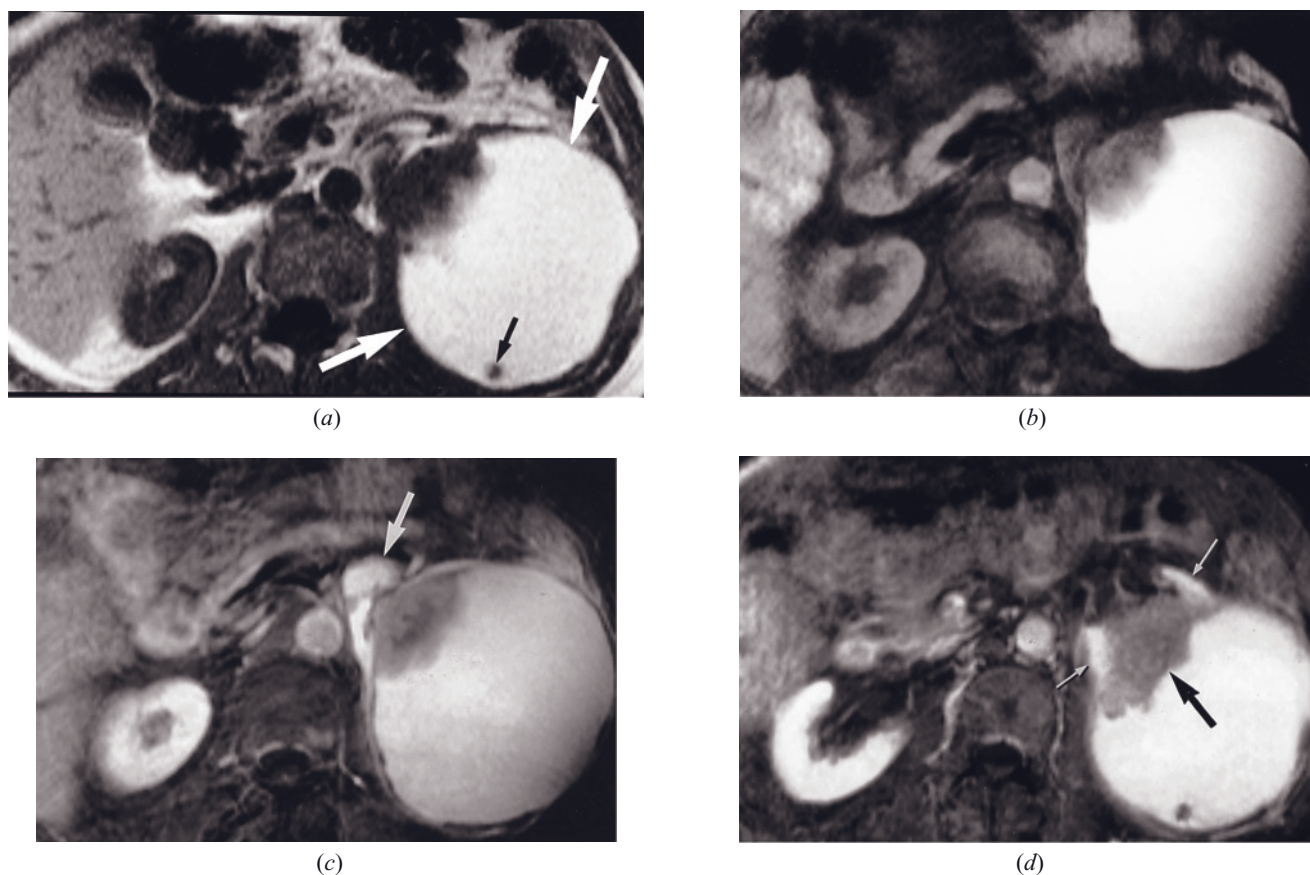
Transitional cell carcinoma, poorly differentiated. T1-weighted precontrast SGE (*a*), precontrast fat-suppressed SE (*b*), and late-phase fat-suppressed gadolinium-enhanced SE (*c*, *d*) images. An irregular tumor arises from the midportion of the kidney and is associated with a large hemorrhagic fluid collection (large arrows, *a*). A small tumor nodule is present in the cystic hemorrhagic component (small arrow, *a*). On the gadolinium-enhanced image, renal parenchyma is well-defined as uniformly enhancing tissue (arrow, *c*). The tumor mass extends from the renal pelvis through the renal parenchyma into the cystic space. Anterior and posterior cortices (small arrows, *d*) are splayed by the irregular tumor mass (black arrow, *d*).
